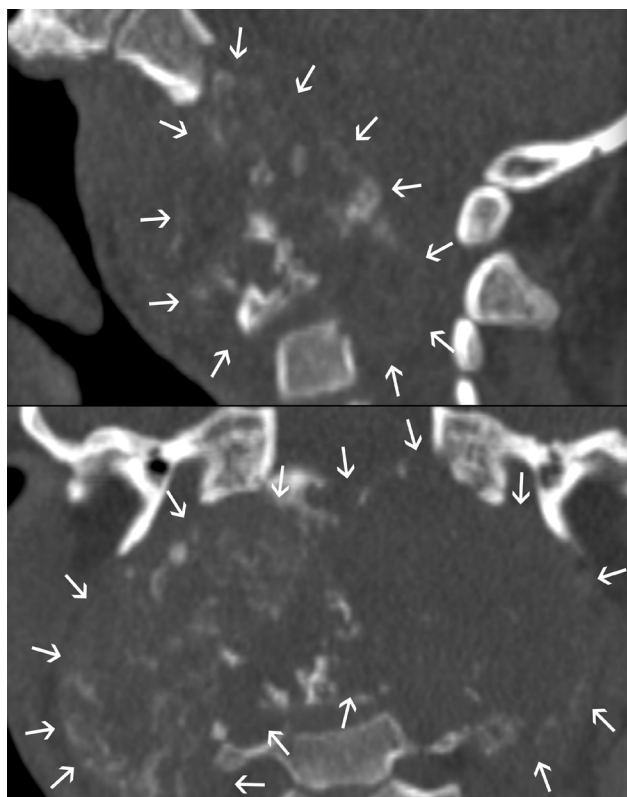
Craniocervical junction chordoma in an 11-year-old boy. Sagittal and coronal reformatted CT images (left and right, respectively) showing a bulky expansile lesion (straight arrows) with a mineralized matrix causing destruction of the inferior clivus, the anterior arch of C1, and most of the C2 body. A large soft-tissue component extends laterally, into the vertebral canal, to the skull base (anterior to the brainstem), and prevertebrally, with bulging of the posterior pharyngeal wall.
